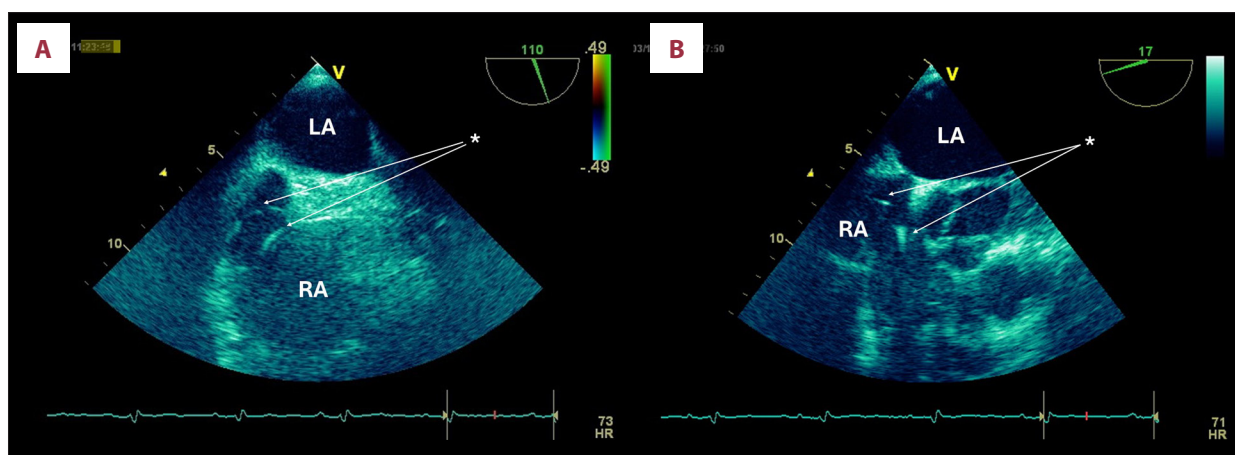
(A, B) Transesophageal echocardiography demonstrating evaluation of the pacemaker leads. No lead-associated vegetations were detected. *, pacemaker lead; LA, left atrium; RA, right atrium.
